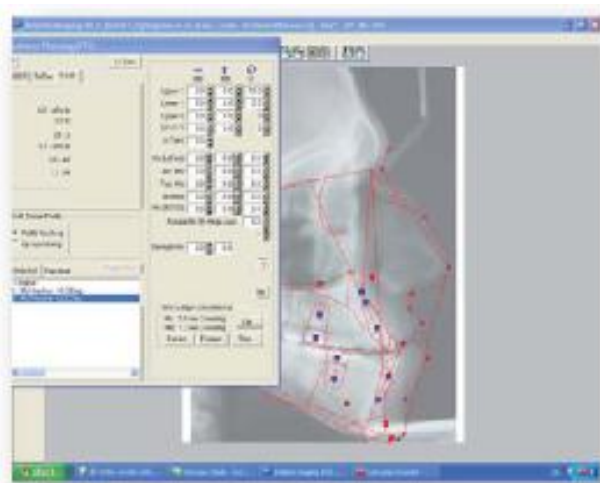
Entering of the data for alterations on the radiographs.
